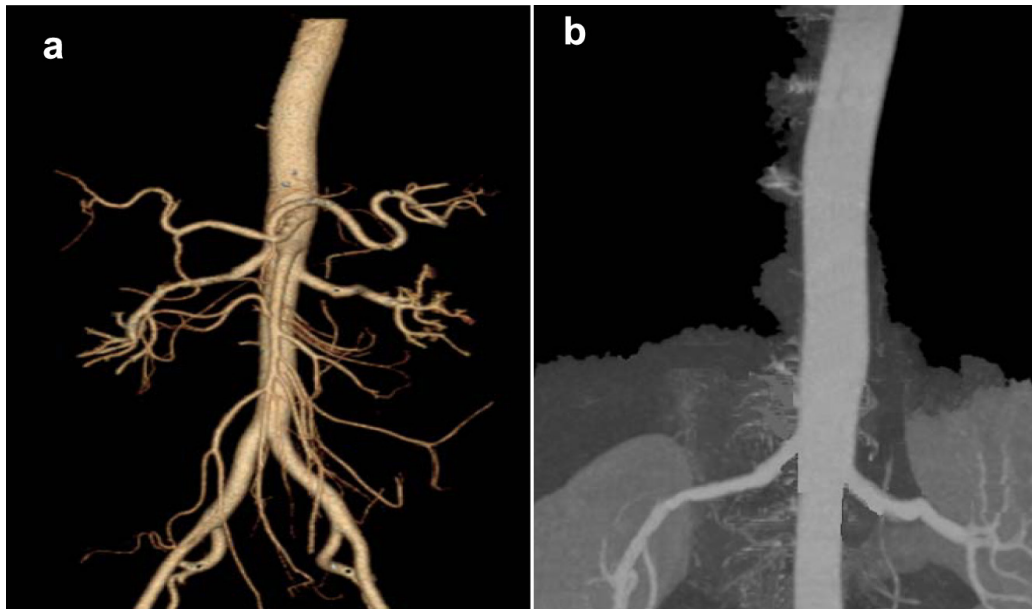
CT images of abdominal aorta and a) arterial branches b) renal arteries
